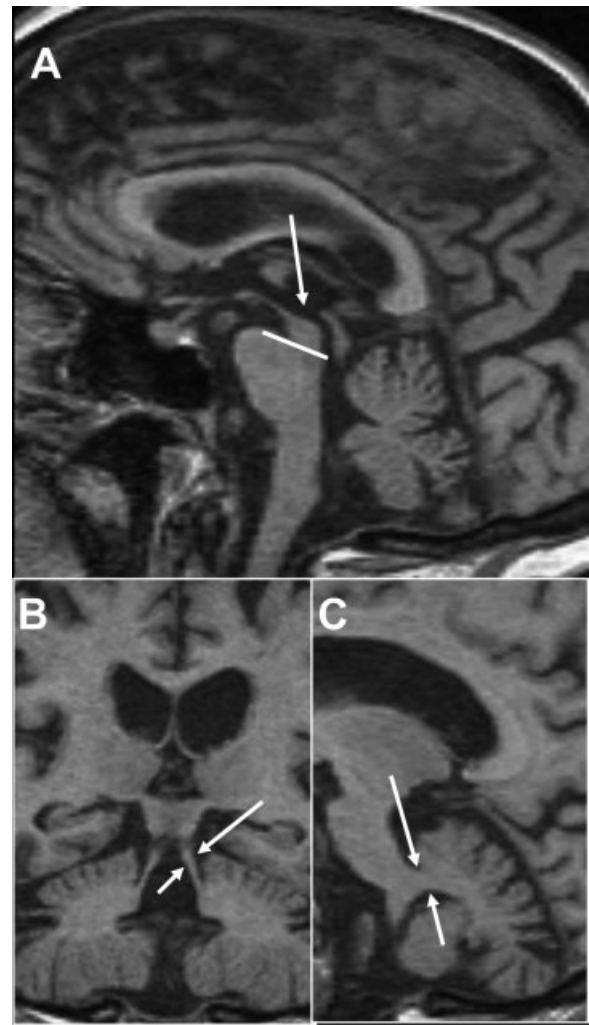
Neuroimaging in progressive supranuclear palsy syndrome (PSPS). (A,B) Sagittal and (C) coronal T1-weighted images from a 61-year-old man with PSPS (MMSE 27) and autopsy-proven FTLT-PSP pathology. (A) Reduced midbrain area (arrow) compared with the pons. Thinned superior cerebellar peduncles on coronal section (B; arrows) are observed compared with the middle cerebral peduncles (C; arrows). Adapted with permission from Vitali P, Migliaccio R, Agosta F, Rosen H, Geschwind M. Neuroimaging in dementia. *Semin Neurol* 2008;28(4):467–483.
